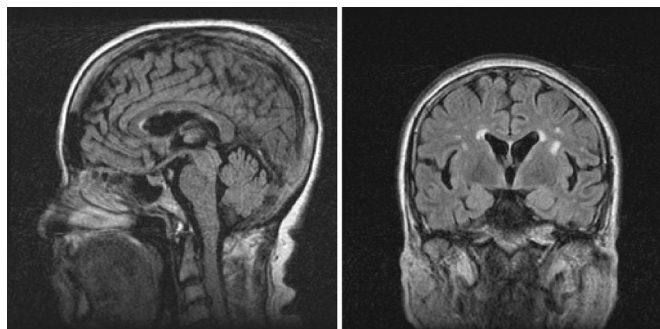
Representative fluid-attenuated inversion recovery sequence MRI brain scans, showing midline sagittal (A) and midhemisphere (B) coronal views. Only minor areas of increased signal are seen in the periventricular regions thought to be on the basis of coincidental, nonspecific chronic white matter ischemia.
